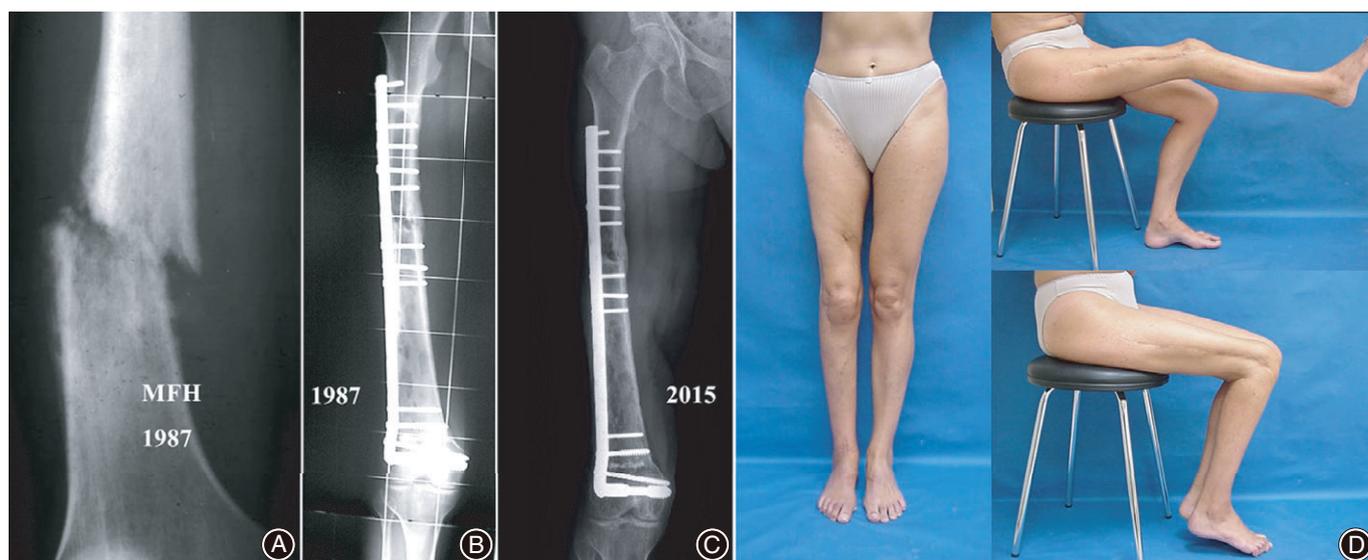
Representative case showing long-term progress of an intercalary allograft of the distal femur after resection of a malignant fibrous histiocytoma in a 28-year-old woman: (A) Preoperative radiograph showing a pathological fracture in the femoral shaft. (B) Radiograph 5 months after resection of the tumor and reconstruction with an intercalary allograft. (C) X-ray film of the femur 28 years after surgery showing consolidation of the graft and some evidence of resorption. (D) Excellent function of the knee at the last follow-up.
